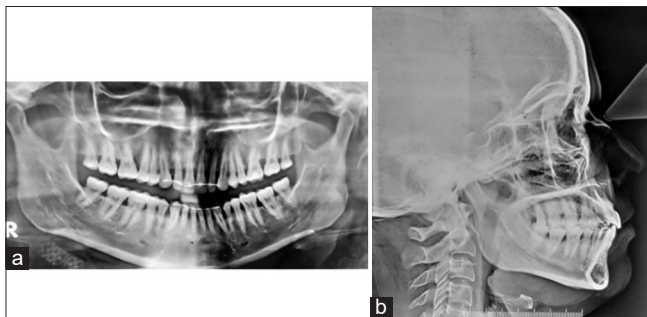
Post-treatment radiographs (a) OPG and (b) lateral cephalogram
